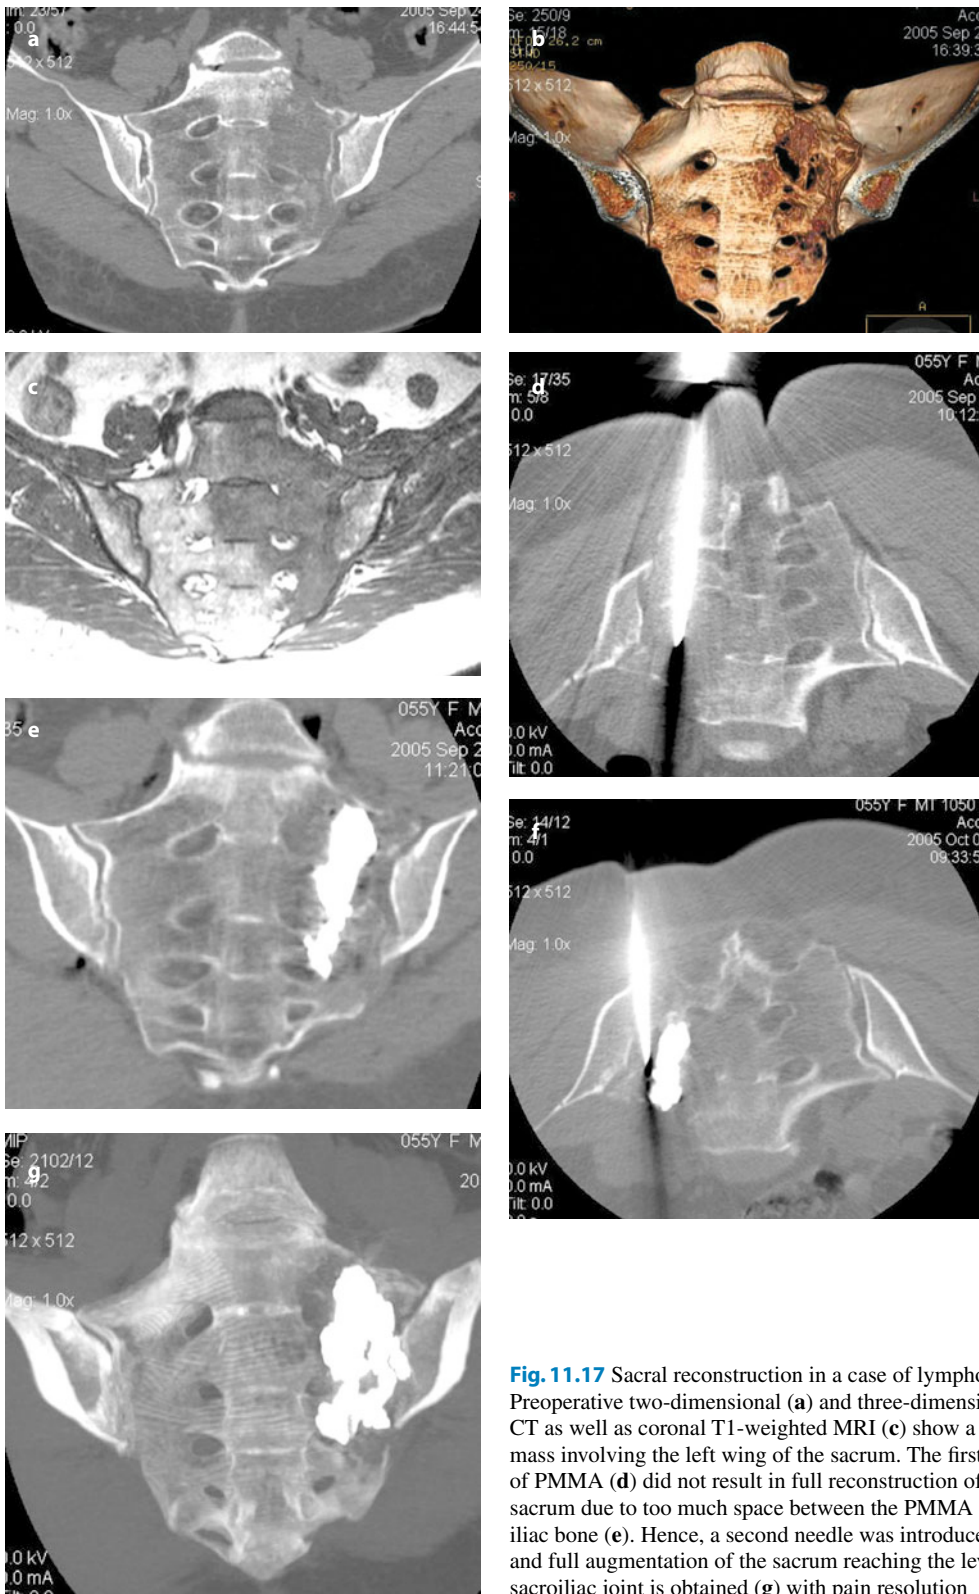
Sacral reconstruction in a case of lymphoma. Preoperative two-dimensional (a) and three-dimensional (b) CT as well as coronal T1-weighted MRI (c) show a large mass involving the left wing of the sacrum. The first injection of PMMA (d) did not result in full reconstruction of the sacrum due to too much space between the PMMA and the iliac bone (e). Hence, a second needle was introduced (f) and full augmentation of the sacrum reaching the level of the sacroiliac joint is obtained (g) with pain resolution
